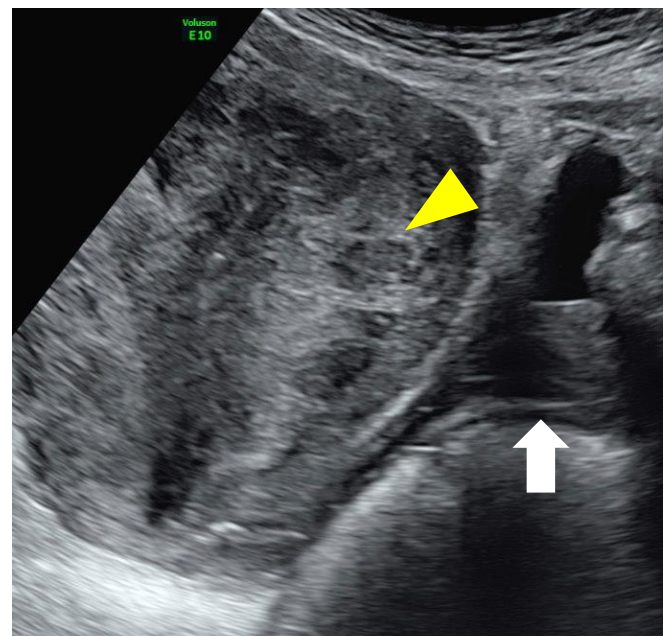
A gynecologic ultrasound shows the gross anatomical configuration. Gynecological ultrasonography shows postpartum ischemic changes in the myometrium of the uterine body (yellow pointer) and a thin, but intact endometrium; however, the vaginal cavity cannot be identified because the uterine body has caused it to collapse (white arrow).
